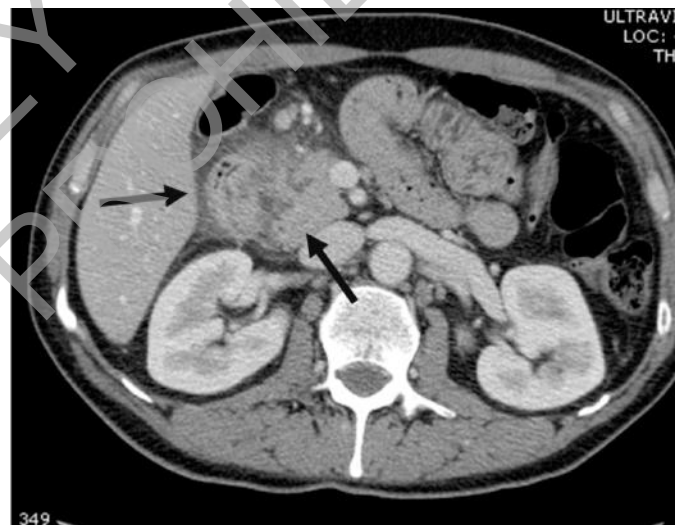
Case 1. CT scan showing a mass-like lesion with cysts of the head of the pancreas obstructing the duodenal lumen (arrows).
